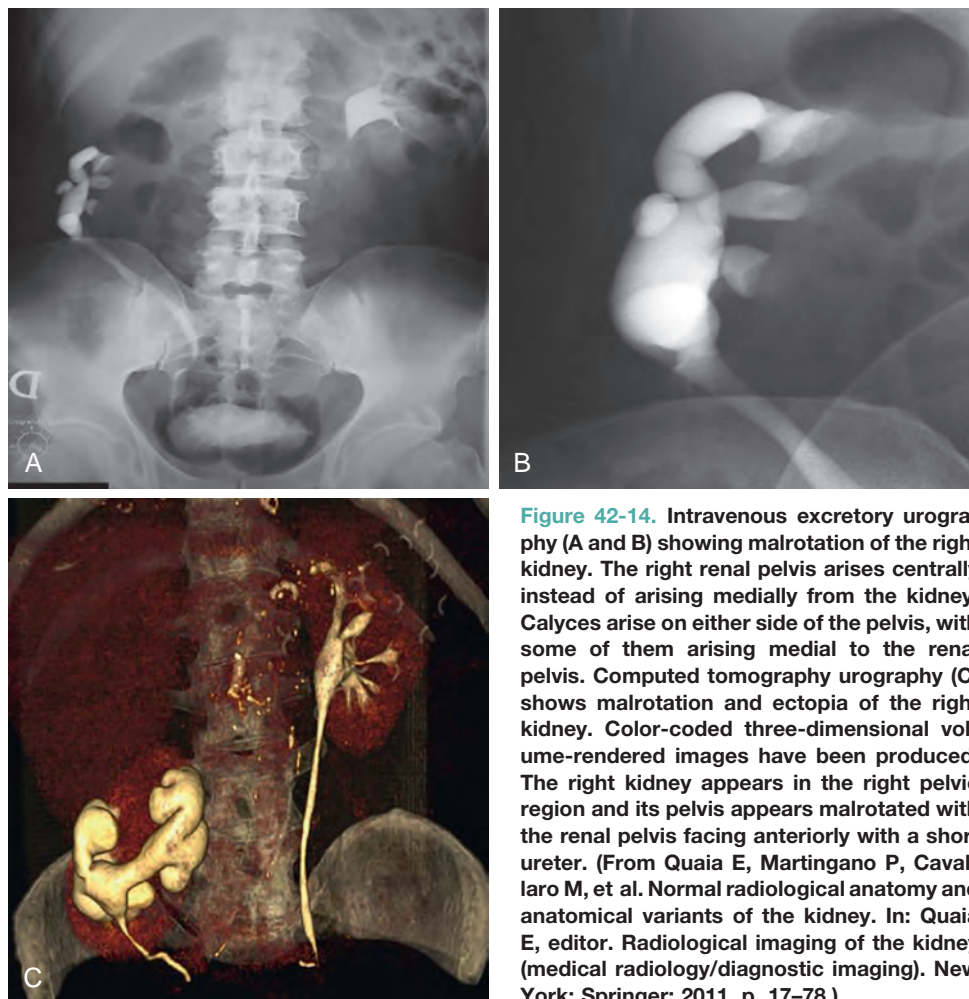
Intravenous excretory urography (A and B) showing malrotation of the right kidney. The right renal pelvis arises centrally instead of arising medially from the kidney. Calyces arise on either side of the pelvis, with some of them arising medial to the renal pelvis. Computed tomography urography (C) shows malrotation and ectopia of the right kidney. Color-coded three-dimensional volume-rendered images have been produced. The right kidney appears in the right pelvic region and its pelvis appears malrotated with the renal pelvis facing anteriorly with a short ureter. (From Quaia E, Martingano P, Cavallaro M, et al. Normal radiological anatomy and anatomical variants of the kidney. In: Quaia E, editor. Radiological imaging of the kidney (medical radiology/diagnostic imaging). New York: Springer; 2011. p. 17–78.)
